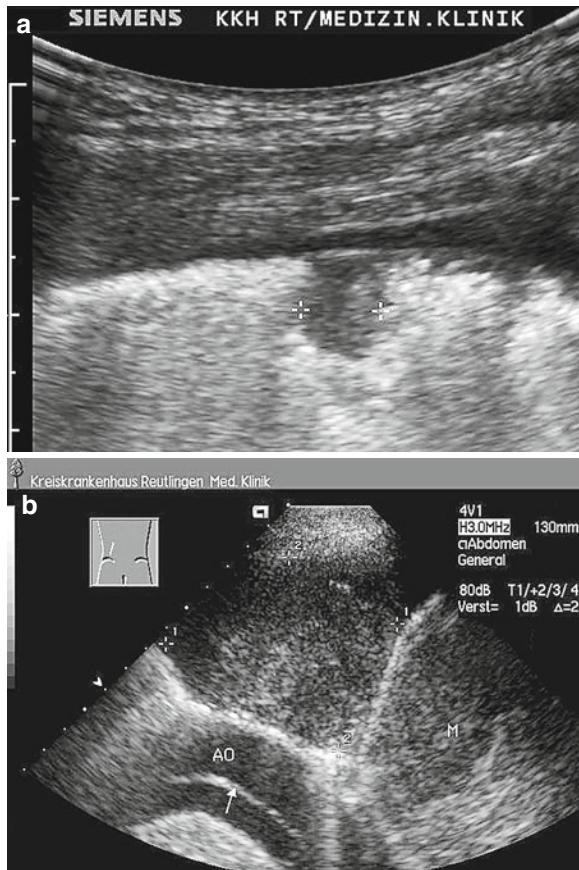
An 80-year-old patient, whose temperature rose rapidly a few days after a fall which injured the left side of the thorax. X-ray image reveals a shadow located on the thoracic wall, suggestive of a fractured rib. Sonographic mass with infiltration into the thoracic wall. Minor liquid movements were perceptible during the dynamic examination. The diagnostic puncture was not successful until a coarse needle (with a diameter of 2 mm) was used. It proved possible to extract highly viscous pus. A pleural drainage was then inserted. Arrows needle shaft
